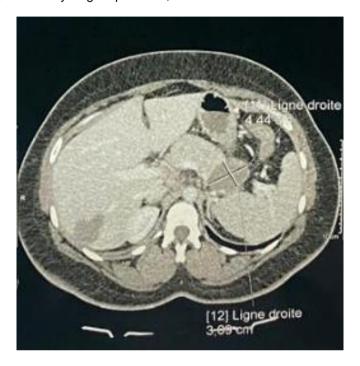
Computed tomography scan showing cystic mass in tail region of pancreas
